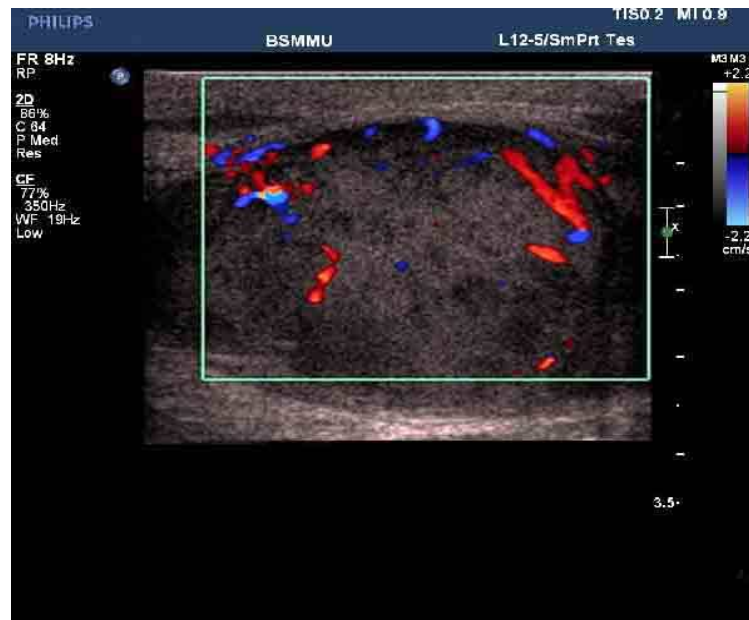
Testicular Tuberculosis-Color Doppler scan showing heterogeneous testis with increased vascularity.
